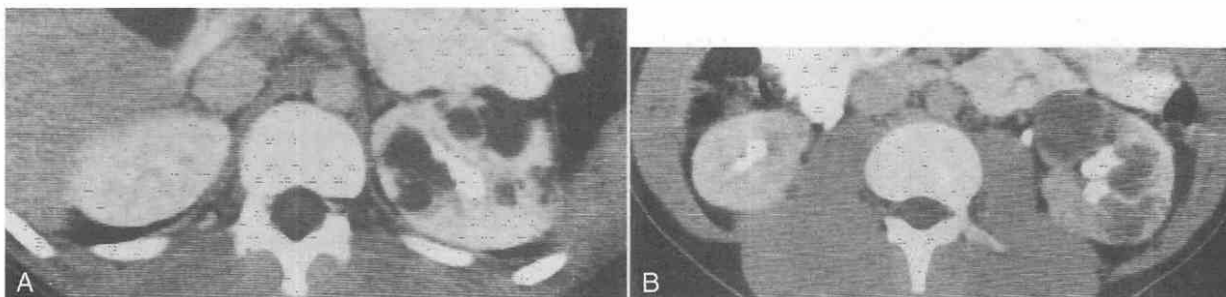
Unilateral renal cystic disease in a 15-year-old male with intermittent gross hematuria starting at 5 years of age. Contrast-enhanced CT scans (A and B) show partial replacement of the left kidney by many cysts that are separated by enhancing bands of normal parenchyma. The right kidney is free of cysts, and a follow-up CT scan 7 years later showed no change.
